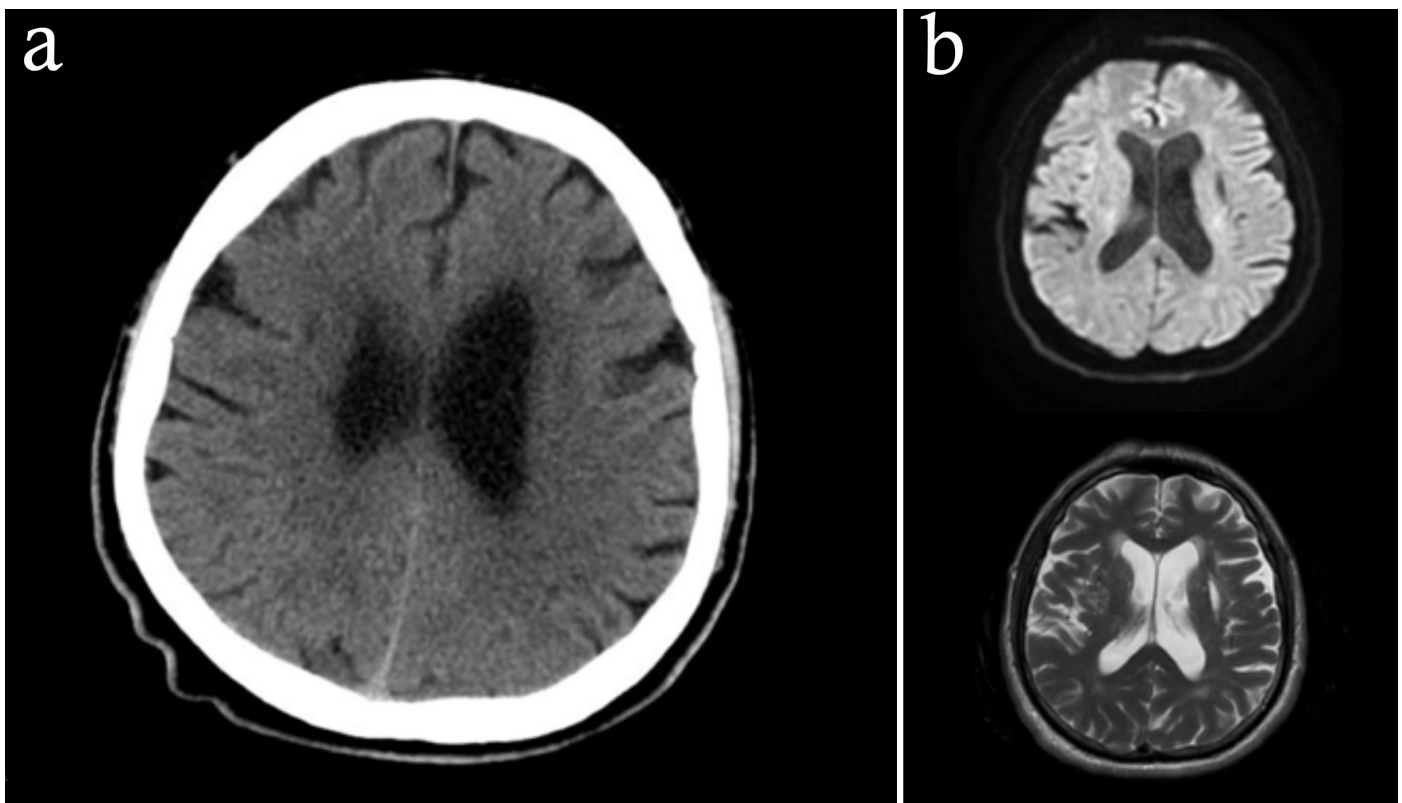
Head computed tomography (CT) (a) and magnetic resonance imaging (MRI-T2 and Diffusion MRI) (b) showed no remarkable findings
